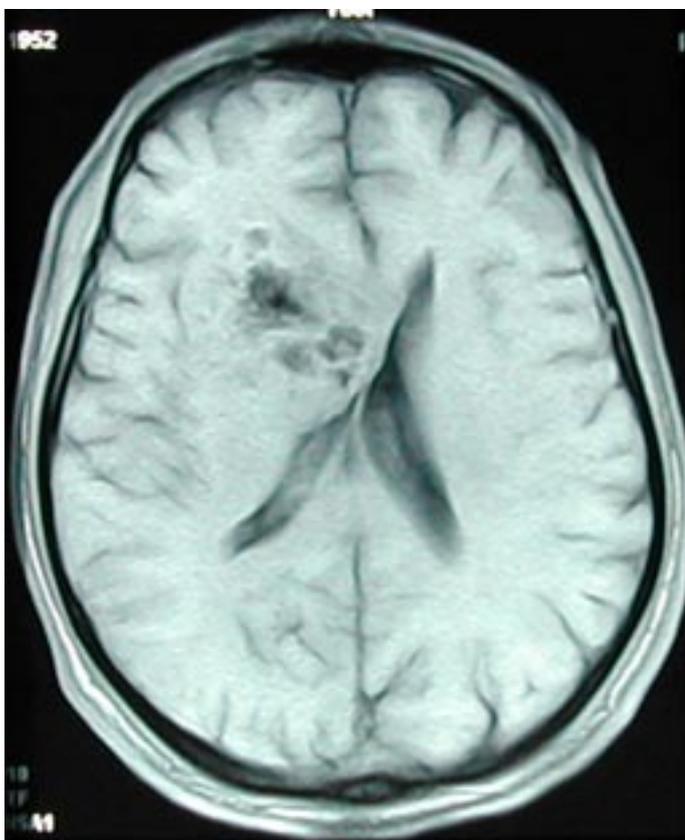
MRI shows mixed signal intensity on T1-weighted image.
